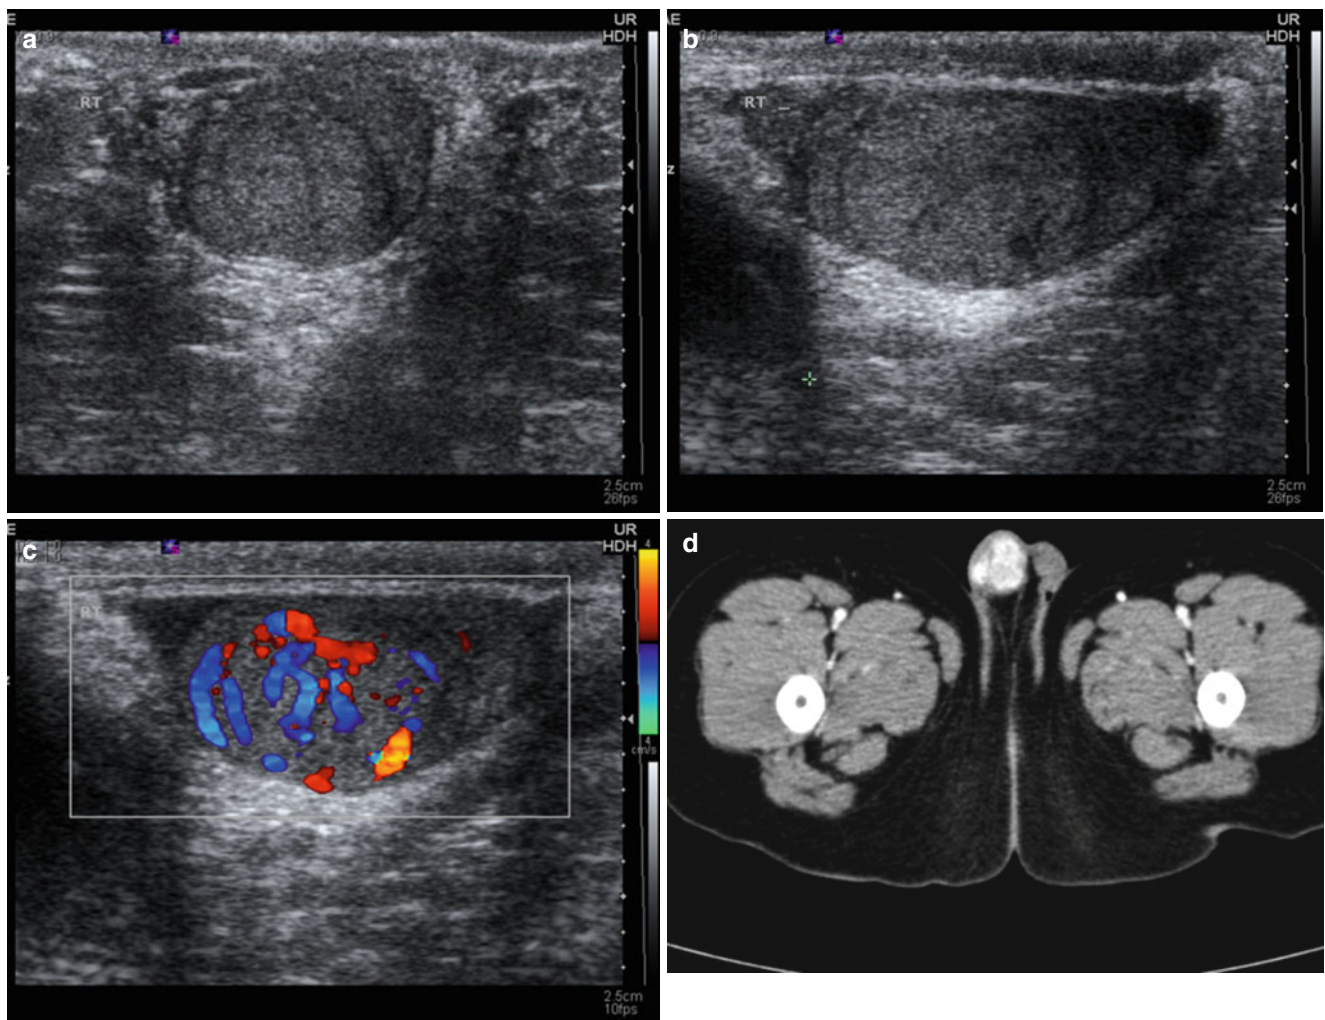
Yolk sac tumor in a 2-year-old boy with scrotal mass. Transverse (a) and longitudinal (b) US scan of the right hemiscrotum show a solid tumor replacing testis. Color Doppler US (c) image shows
